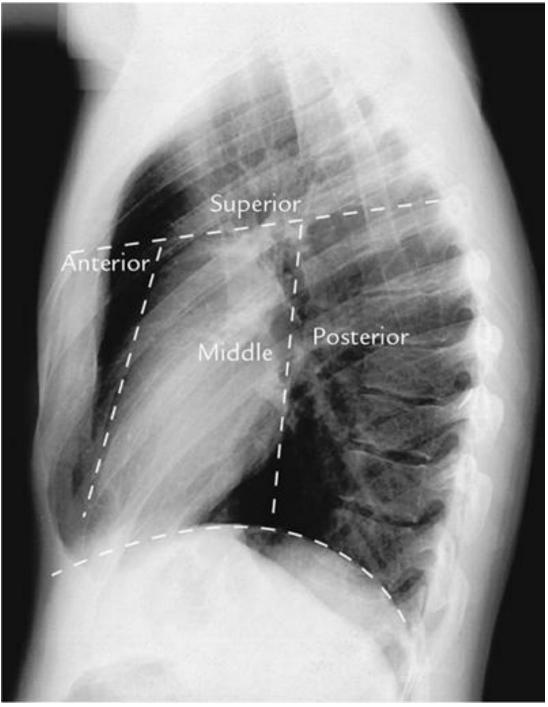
Parts of the mediastinum demonstrated on a chest radiograph (lateral view). (*Source* : *Integrated Anatomy* : David J.A. Heylings, Roy A.J. Spence, Barry E. Kelly, Fig. 4.13, p. 99, Elsevier Limited, 2007.)
